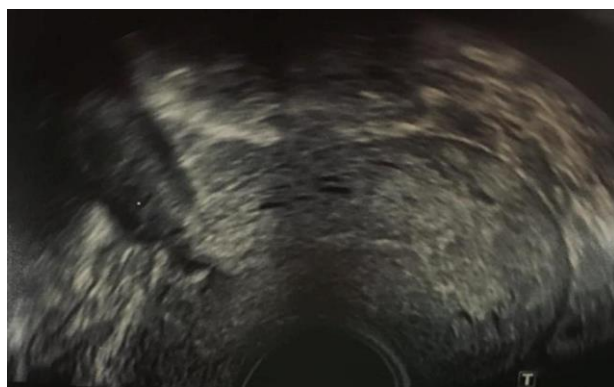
Post-surgery ultrasound.
